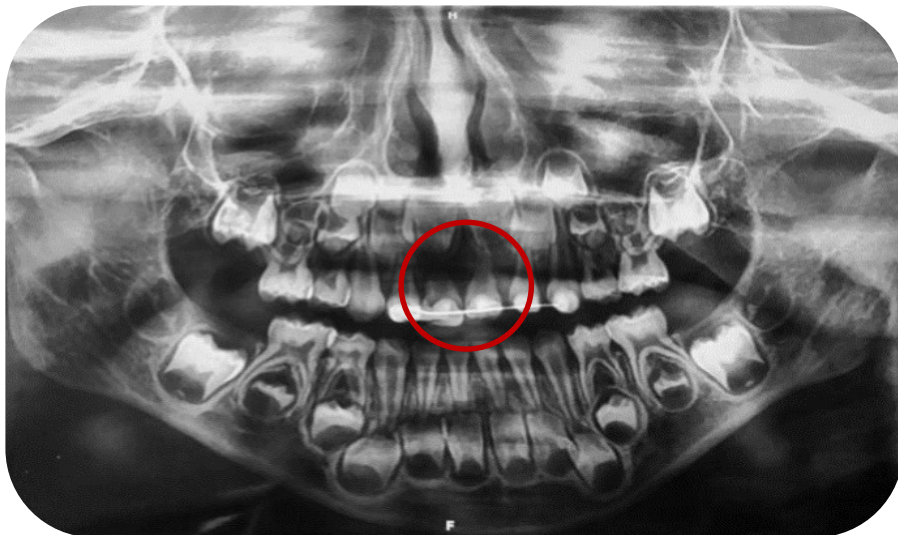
Panoramic radiograph showing pathologic root resorption of the splinted primary central incisors
